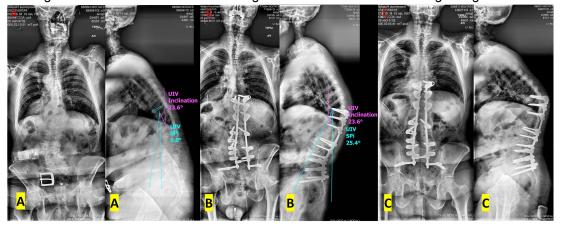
(A) Baseline, (B) 6 weeks, and (C) 1 year anteroposterior and lateral standing radiographs of a patient with preoperative Landing Zone listhesis, iatrogenic UIV SPi, and PJK/PJF.
